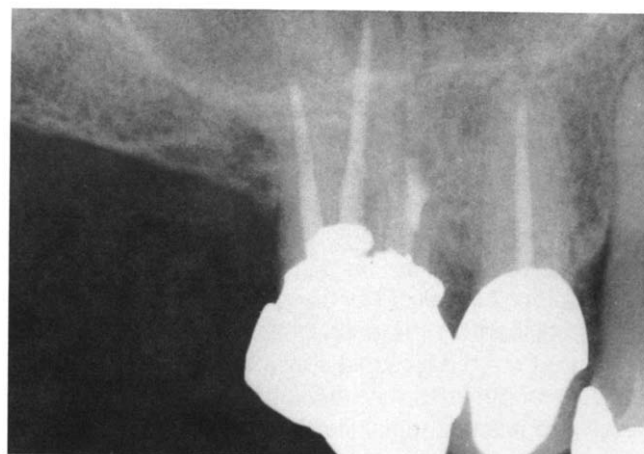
Immediate postoperative retrofilling radiograph.
